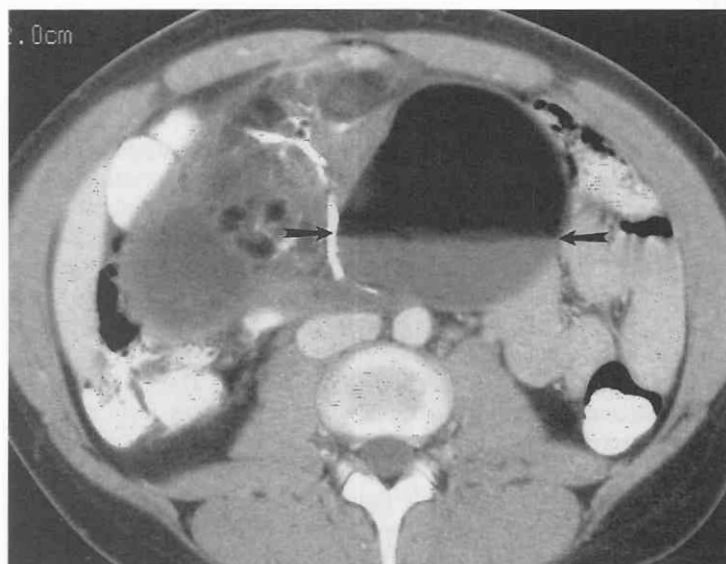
Teratoma. Contrast-enhanced abdominal CT scan reveals a large heterogeneous teratoma in the midabdomen of a 24-year-old woman. The teratoma contains elements that show the attenuation of calcification, soft tissue, fluid, and fat. A fat-fluid level can be seen in one component (arrows).
